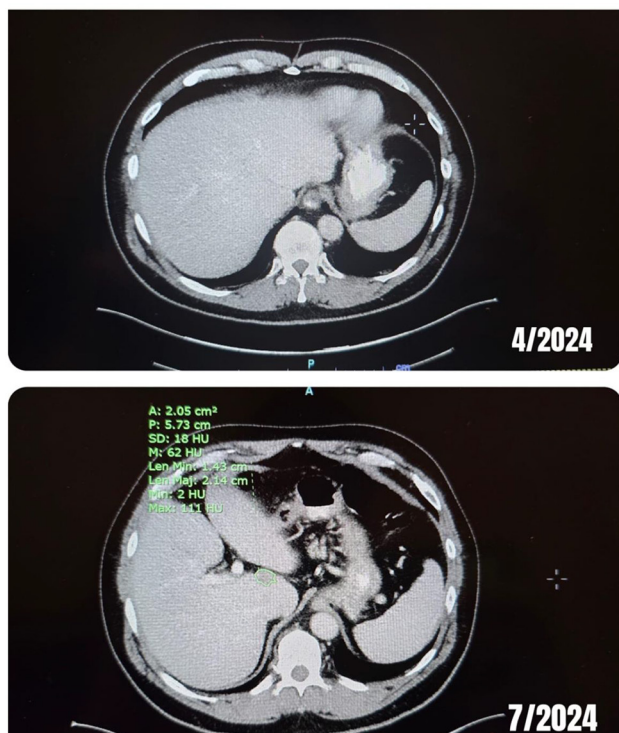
Contrast-enhanced axial computed tomography (CT) images of the liver in Case 1. (A) No focal hepatic lesion is visible 4 weeks after completion of adjuvant chemotherapy. (B) Twelve weeks later, CT demonstrates a 2.1-cm hypoattenuating right hepatic lesion (arrow) detected after ctDNA positivity, consistent with oligometastatic recurrence subsequently managed with partial hepatectomy.
